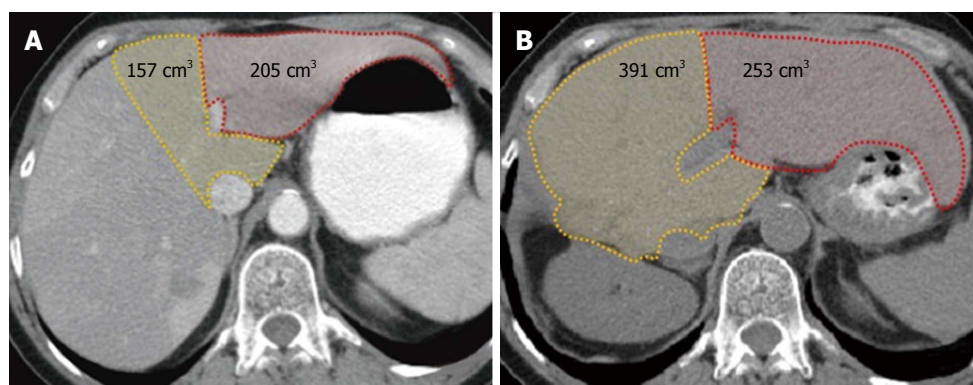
Computed tomography-based volumetry. A: Before the first stage of liver resection; B: Before the second stage of the procedure. Modulated congestion of the left lobe associated with right hepatectomy led to a significant hypertrophy rate of segments 4 and 1 (156%) but only a modest hypertrophy rate of segments 2 and 3 (24%). Modified from Balzan *et al*^[15].
